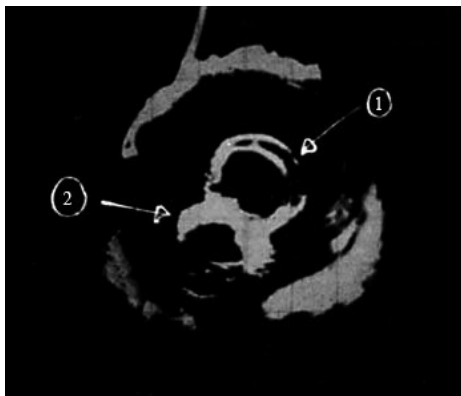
Transabdominal ultrasound scan showing (1) the double ring of the meningocele with (2) the fetal head lying deep to it. (Reproduced with permission from Michell et al., *J Obstet Gynaecol Br Commonw* 1973;80:1100-1).
